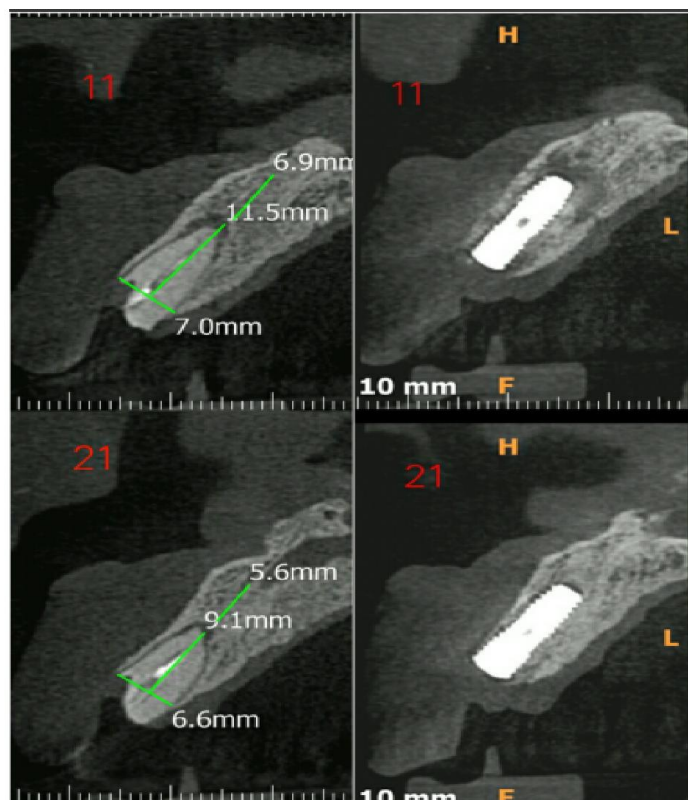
CBCT after 8 weeks of placement revealing peri implant bone adaptation
